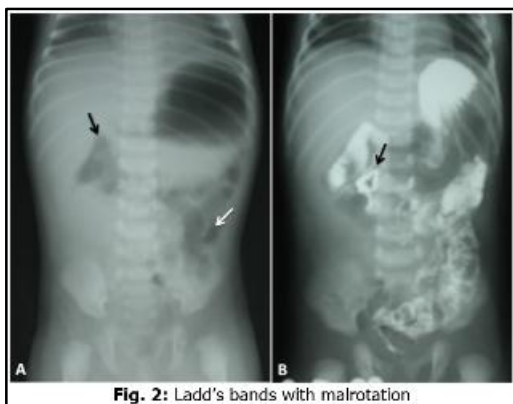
(A). Plain X-ray Erect Abdomen shows dilated gas filled stomach and duodenum with abrupt cut off (black arrow). All the bowel loops are placed on the left side (white arrow). (B). Barium meal follow through study confirms the findings.
